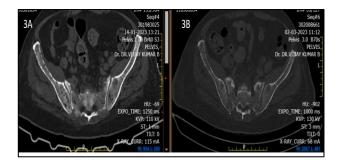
(A, B): MRI images showing steady improvement in patient.
